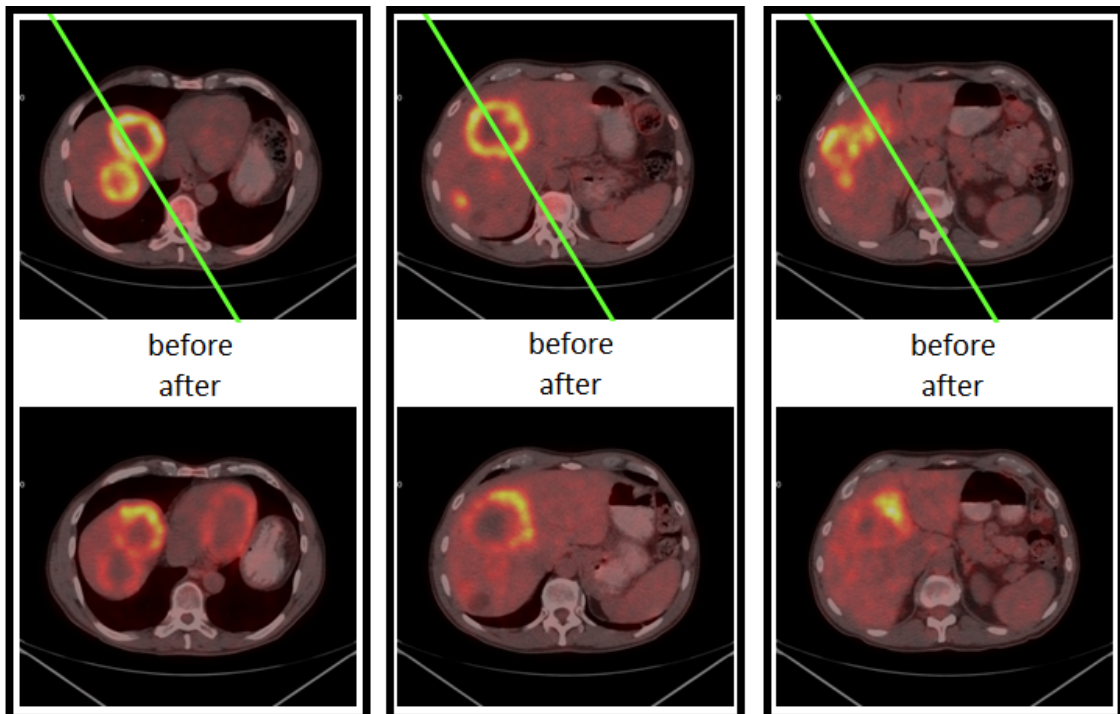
(^{18}F)FDG PET-CT before and after treatment in three patients, lower half of the liver (left of green line) treated with Chemo-RMT, other half (right of line) treated with Chemo only (59) demonstrating improved response of RMT combined with chemotherapy and the potential for “highly” RMT.
